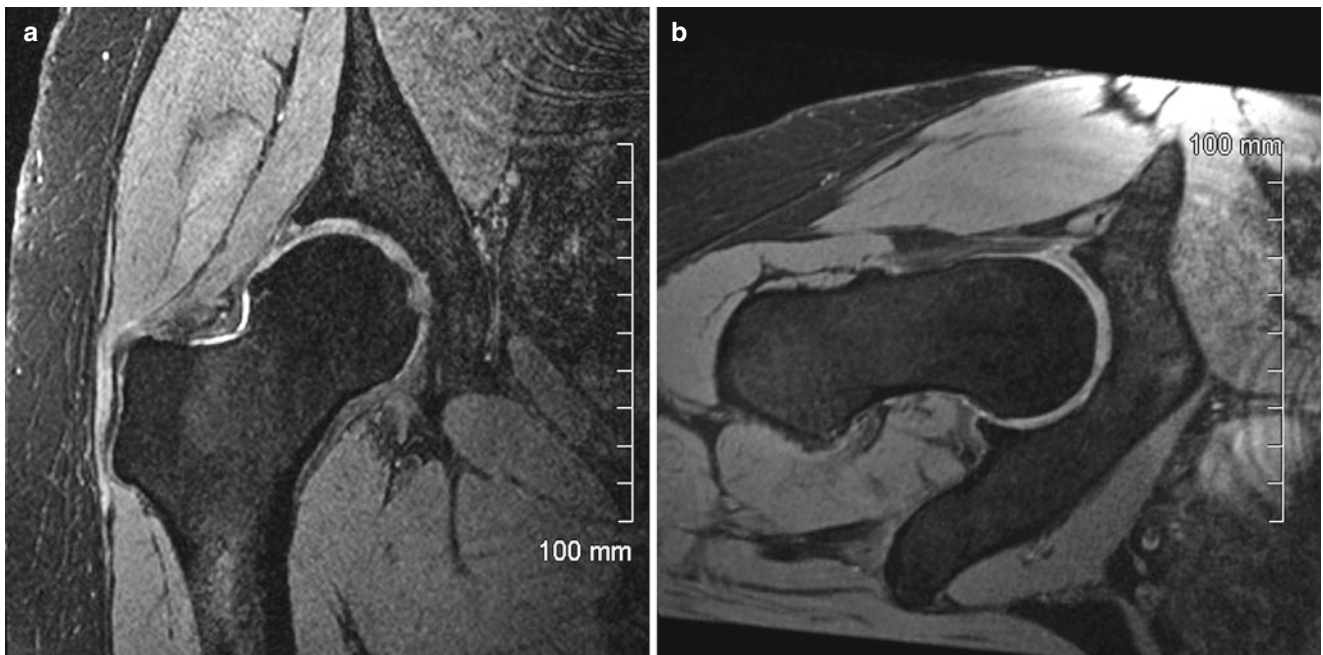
Healthy 35 year old female patient with clinical and radiographic CAM type FAI whose radiographs are shown in Fig. 15.1. Selected cuts from coronal (a) and radial (b) MR imaging of the patient's right hip further delineate her CAM lesion and labral pathology
